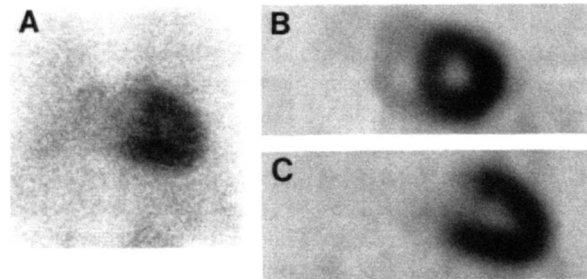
Thallium-201 scan performed in a 50-yr-old female following maximal (90% age-predicted heart rate) treadmill exercise. Five-minute anterior (A) and subsequent SPECT midventricular short-axis (B) and vertical long-axis (C) slices are shown. Tracer concentration in the liver is minimal.
